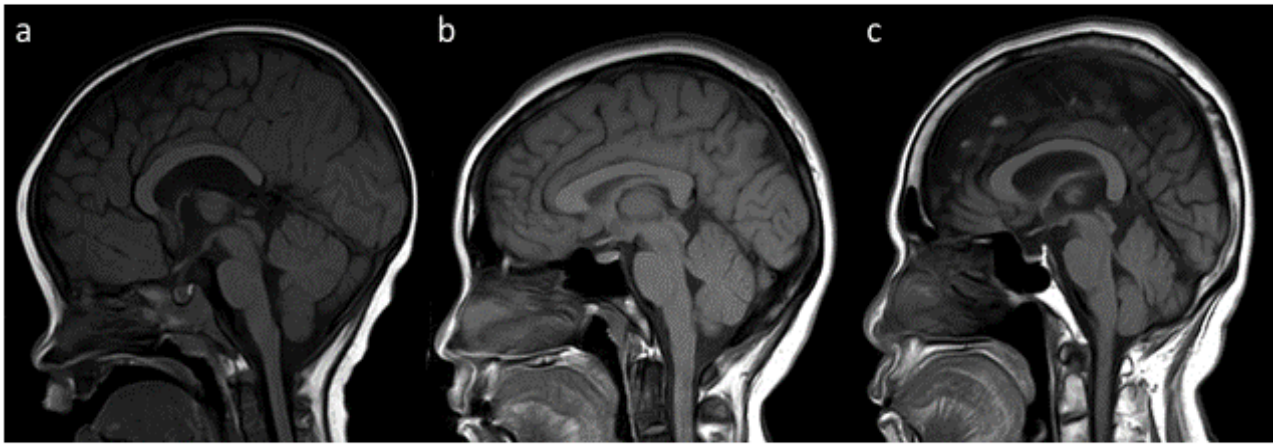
Midsagittal T1-weighted MR imaging of normal clivus bone marrow on qualitative assessment. (a) Grade I in 1-year-old boy (b) Grade II in a 32-year-old female (c) Grade III in a 75-year-old female.
